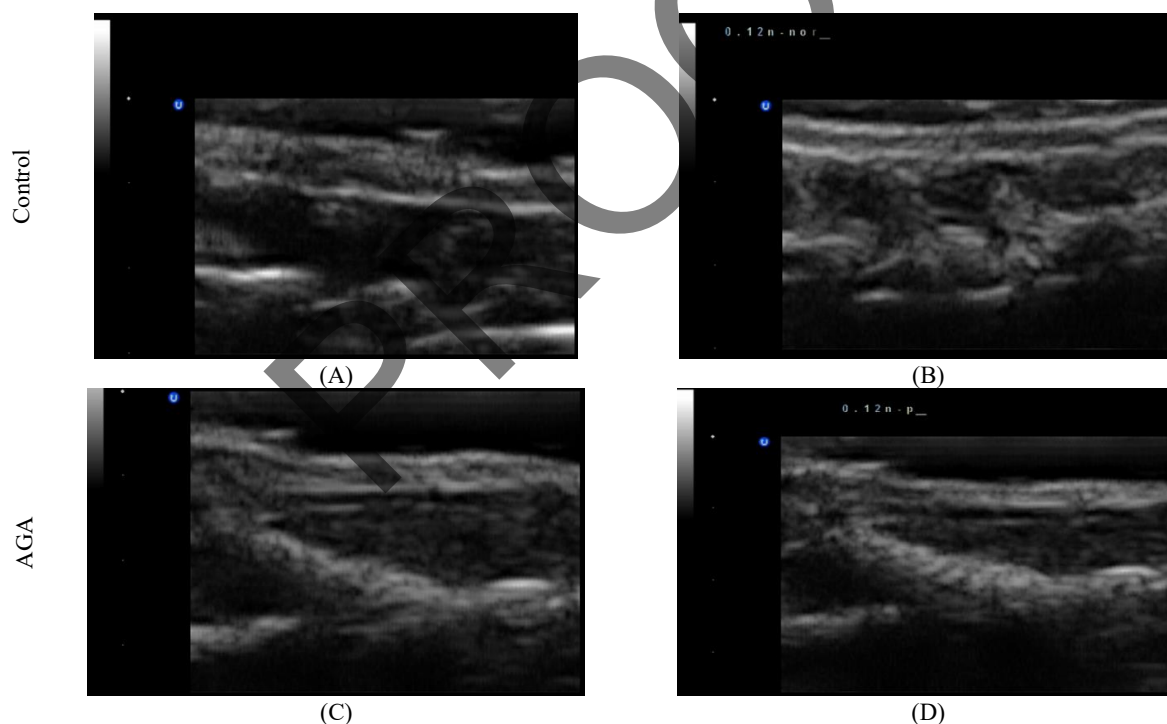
Ultrasound images of the skin tissue on day 19 after epilation with a 40 MHz device: (A and C) before applying stress, and (B, D) after applying stress (0.12 N) of the control and the AGA groups
